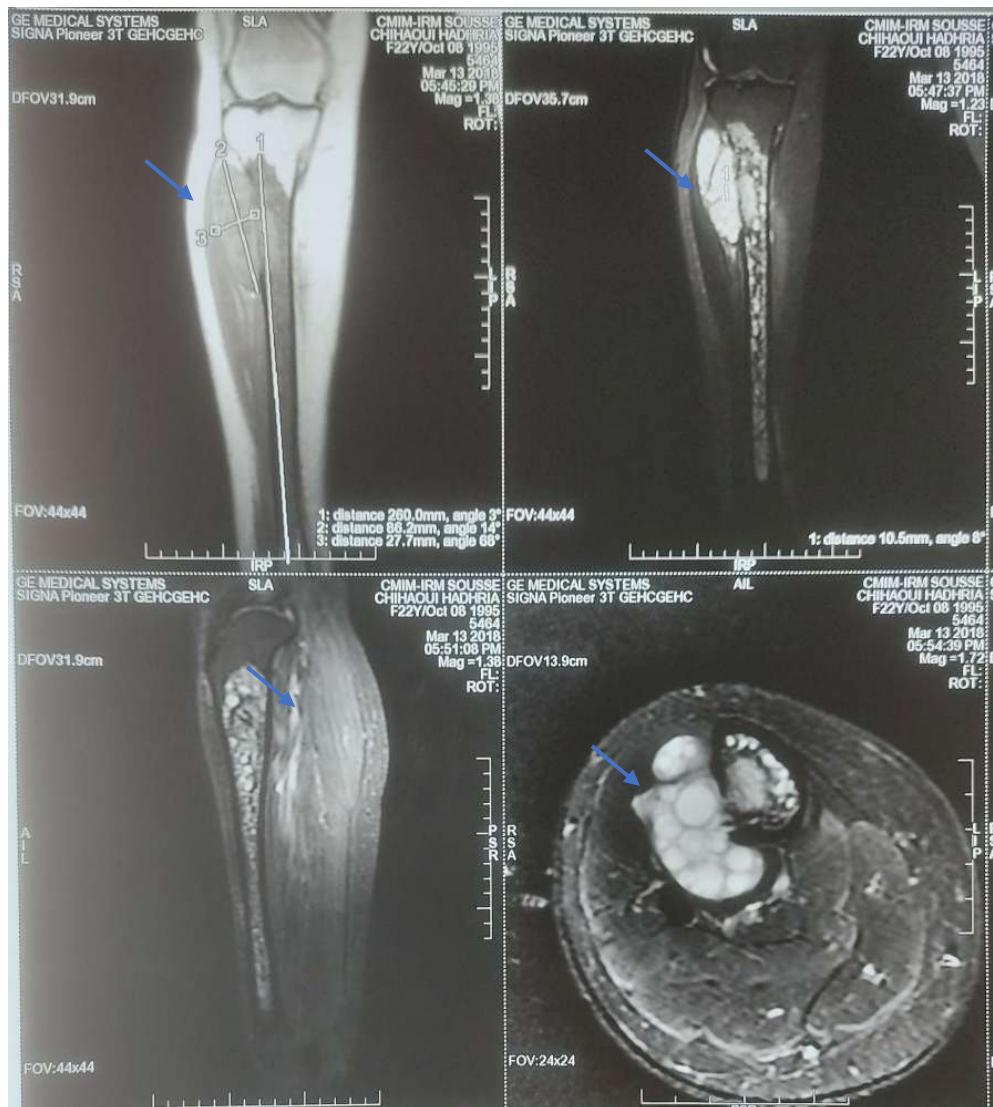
MRI showing an osteolytic mass in the proximal metaphysis of the tibia extending to the subchondral bone displaying a heterogeneous appearance and enhancement that delineates cystic areas
